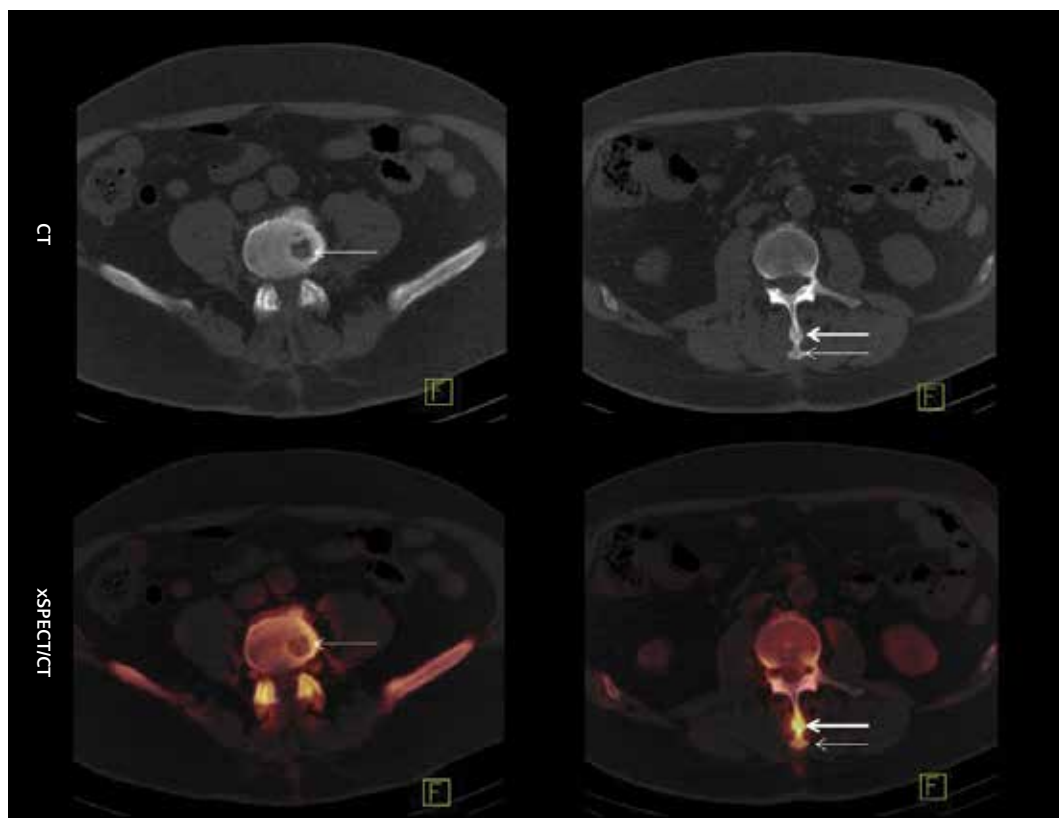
CT and fusion of xSPECT Bone and CT through the L4 end plate (left column), show a large subchondral cyst (arrows) in the L4 vertebral end plate, with reactive hypermetabolism in the cyst margin and adjacent part of the end plate, as well as bilateral intervertebral facet arthropathy. Images through the spinous process of the L2 vertebrae (right column) show hypertrophied ends of the spinous process with hypermetabolism (arrows) that is secondary to approximation and friction with the adjacent L1 spinous process (Baastrup's sign). The fracture line in the L2 spinous process, the bony hypertrophy as a reaction to the fracture and related friction due to approximation with the spinous process above, and the resultant hypermetabolism in the region of the fracture and hypertrophy is clearly delineated (bold white arrow) in the images with fusion of CT and xSPECT Bone.
